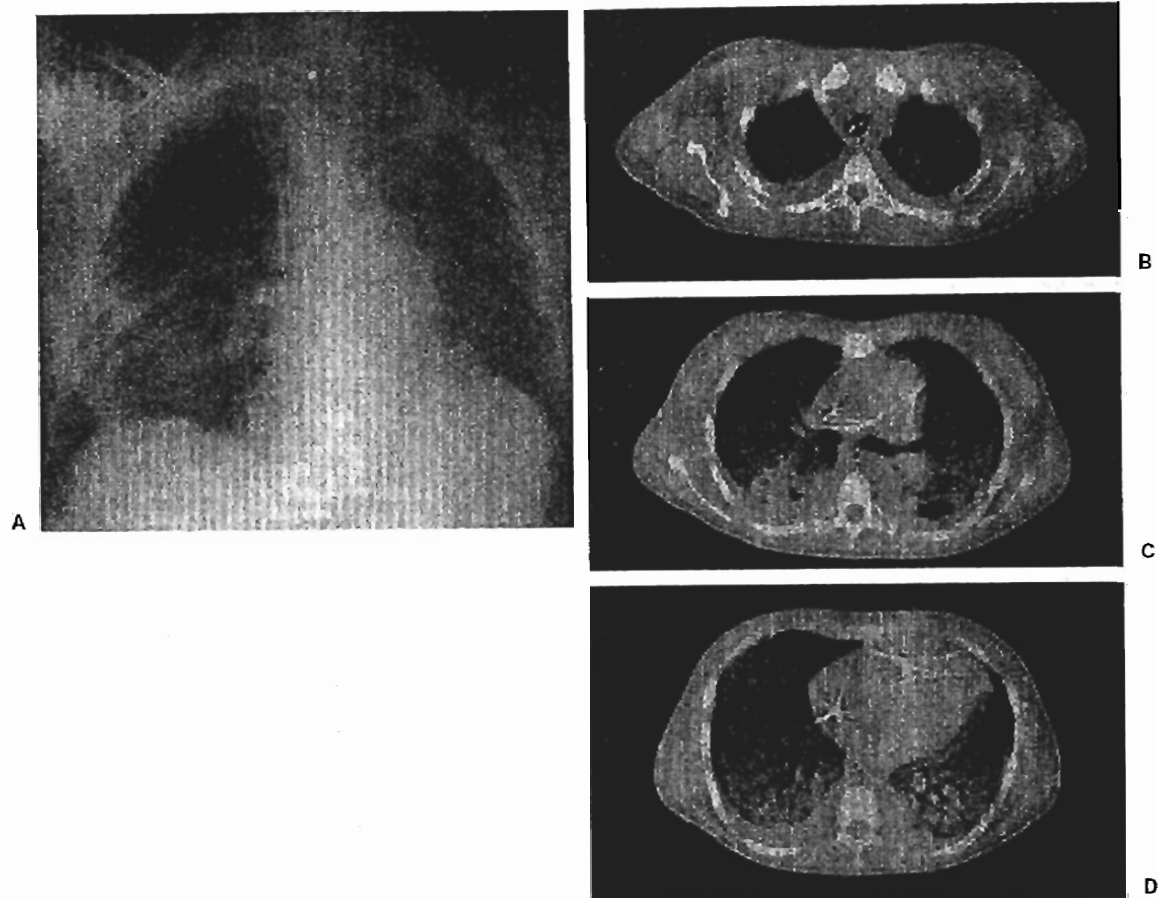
Anteroposterior chest x-ray (A), and corresponding lung computed tomographic (CT) scan images at apex, hilum, and base (B,C,D) of a patient affected by acute respiratory distress syndrome (ARDS) from sepsis. CT scanning was performed at end-expiration, at a positive end-expiratory pressure (PEEP) of 5 cm H₂O. Although the chest x-ray shows diffuse ground-glass opacification, sparing the right upper lung, the CT scans revealed an inhomogeneous disease, with both craniocaudal and sternovertebral gradients. From Gattinoni et al,¹⁶ with permission.
